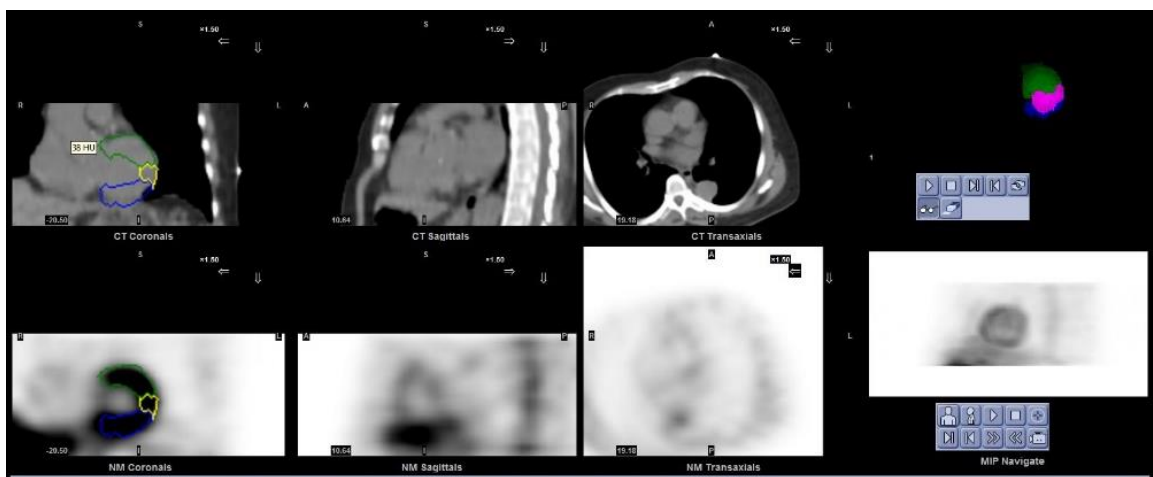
shows the SPECT/CT image of Patient 1
